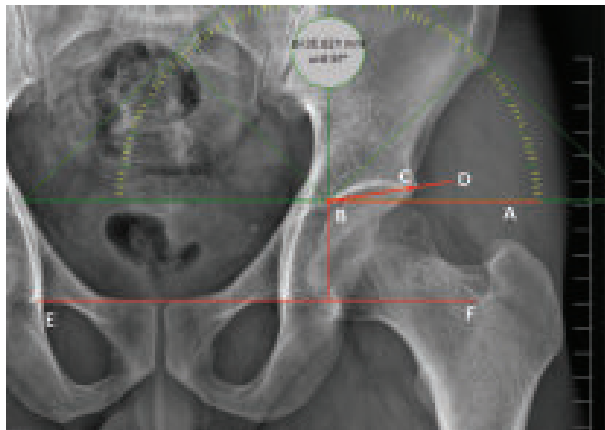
Plain digital radiograph of pelvis AP view showing measurement of Tonnis angle
